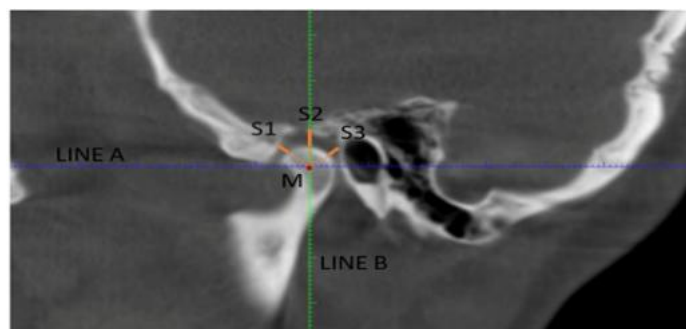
Assessment of condyle–fossa relationship on sagittal CBCT section.
